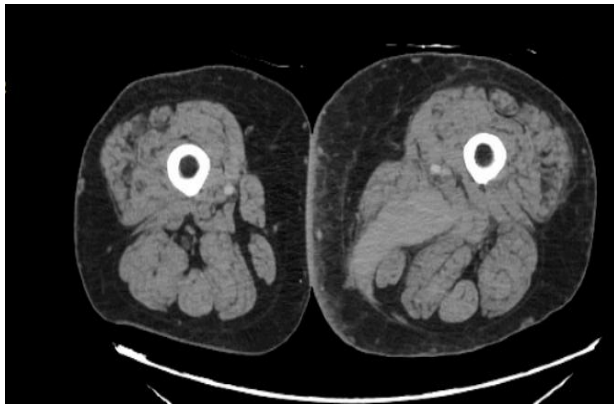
CTA abdominal aorta and bilateral iliofemoral runoff showing persistent 11×5 cm left posteromedial compartment hematoma.
